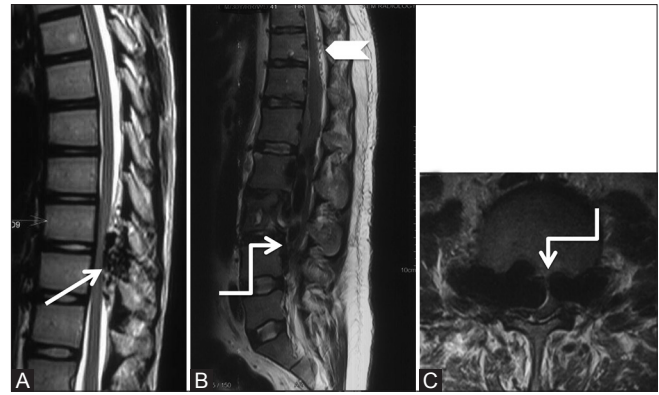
(A-C): Benign: Paraspinal Arteriovenous Fistula: 26-year-old male with a history of low backache and paraparesis. Sagittal T2-weighted image at lower thoracic (A), Sagittal (B), and axial images (C) through the lumbar spine show presence of multiple flow voids (arrows) in the posterior epidural space in lower thoracic region, displacing the thoracic cord anteriorly. Multiple flow voids are also seen on the surface of cord due to dilated perimedullary veins (arrowhead). Massively dilated anterior epidural venous plexus and intervertebral veins (elbow arrow) are seen compressing the cauda equina and scalloping the lumbar vertebral bodies
